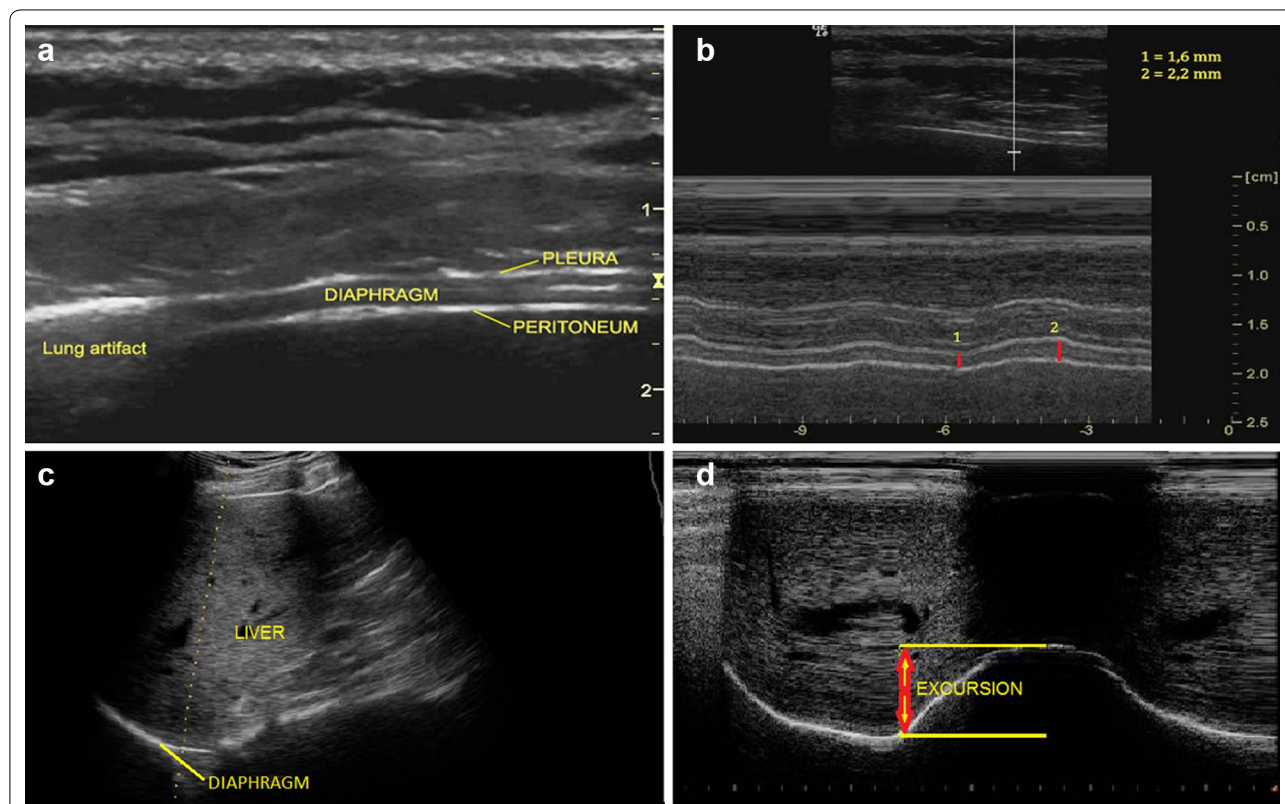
Diaphragm ultrasonography (DU) at the zone of apposition in a B-mode, b M-mode. 1 Thickness at end expiration, 2 thickness at end inspiration. DU, right subcostal in c B-mode, d M-mode
